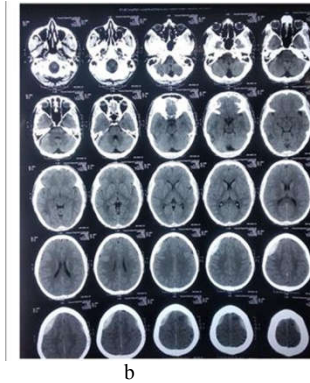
Figure v (Patient 5): Hematoma size increased. Surgical evacuation was done. (a) CT head on admission (b) CT head on 3rd post admission day (c) CT head 2nd Post-operative day.
